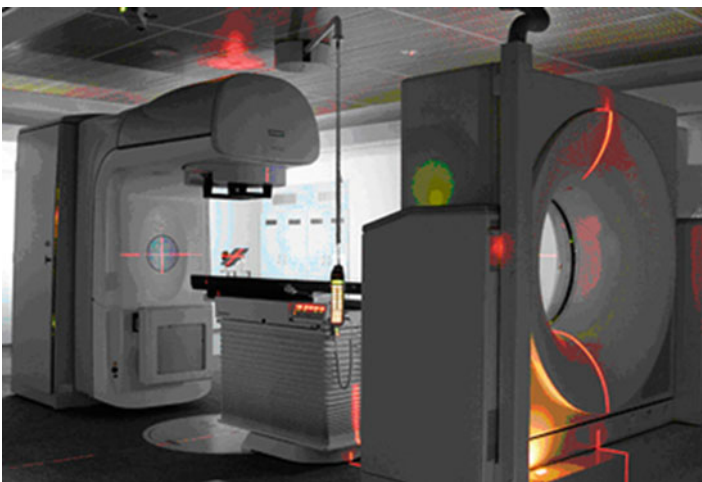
CT on rails combined with a LINAC [42]
